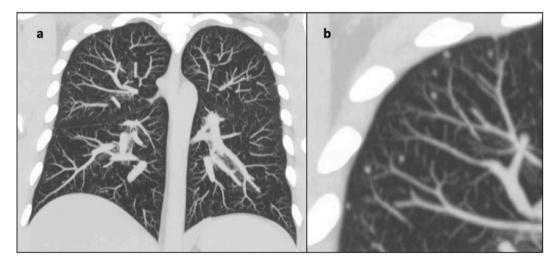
Computed tomography images at presentation. a. Coronal overview. b. Zoomed in portion of right apical corner.
